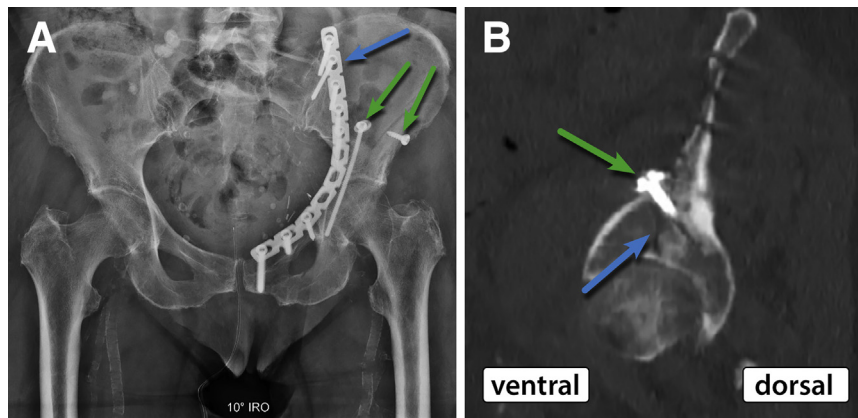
(a) Postoperative X-ray of the pelvis showing the final result after endoscopic-assisted plate fixation of the left acetabulum. On the left side the large-fragment titanium reconstruction plate is (blue arrow). Two further compression screws are visible (green arrows). (b) Postoperative computed tomography scan of the pelvis in sagittal view after plate fixation. One screw and parts of the plate are visible (green arrow). The fracture line is marked with a blue arrow. Anatomical reduction is achieved (Compare Fig. 1b).
